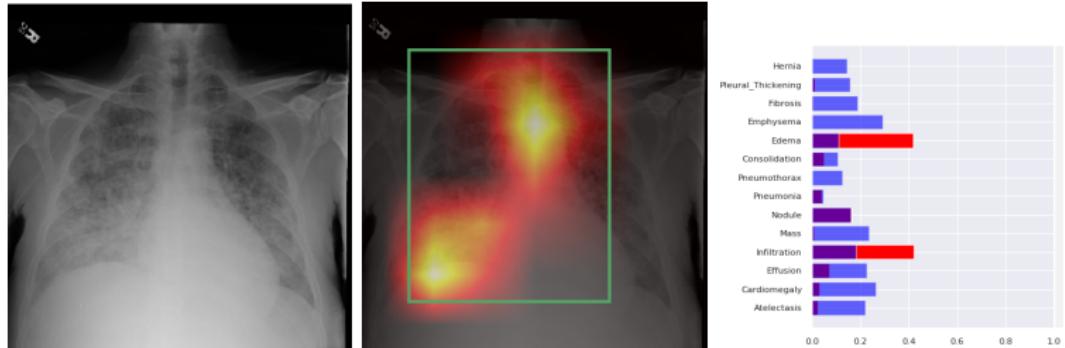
Original image, image overlaid with saliency map and bounding boxes for *Edema*, and predicted probabilities for an x-ray image.
